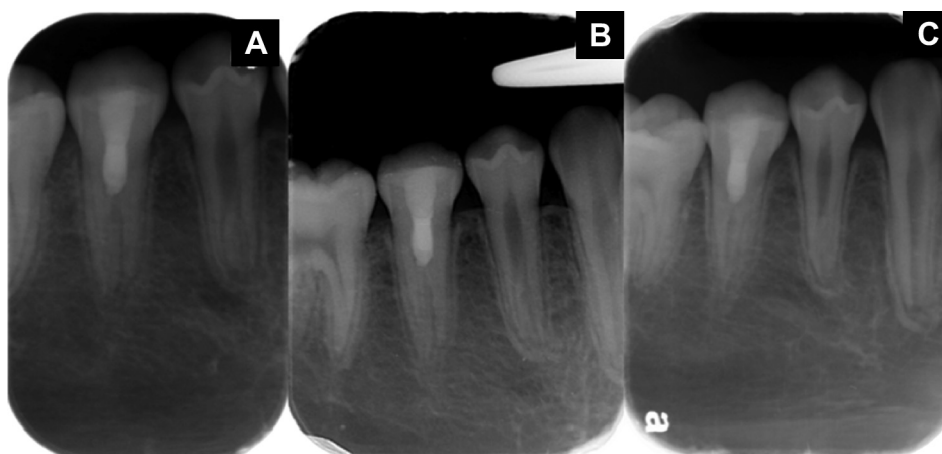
(A) Six-month follow-up radiograph showing complete resolution of radiolucency. (B) One-year follow-up radiograph revealing an increase in the thickness of the root canal wall and continual development of the apex. (C) Seventeen-month follow-up radiograph depicting continual root development.
